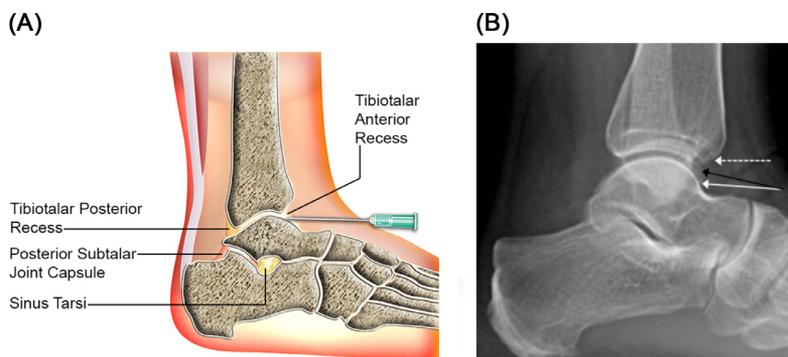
Lateral ankle images demonstrating the potential needle trajectories. Anatomic rendering (A) showing the extent of the tibiotalar joint capsule and anterior recess. (B) Lateral ankle radiograph showing the oblique needle trajectory (black arrow) for intra-articular access and less oblique course (solid white arrow) for capsular recess access using the anterior talar approach. If the radiolucent tibiotalar space (dotted white arrow) is targeted directly on the frontal view (not shown), this results in a more superior needle path with joint access more difficult due to the distal tibial lip particularly in patients with large overhangs or osteophytes.
